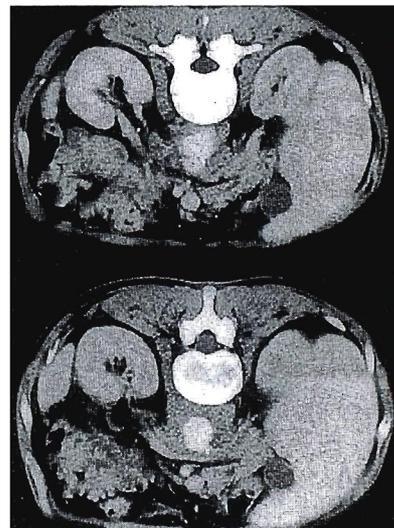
An abdominal computed tomography (CT) scanning, the day before admission, showing a saccular suprarenal aortic aneurysm with periaortic edema and hypofunctioning the right kidney.
